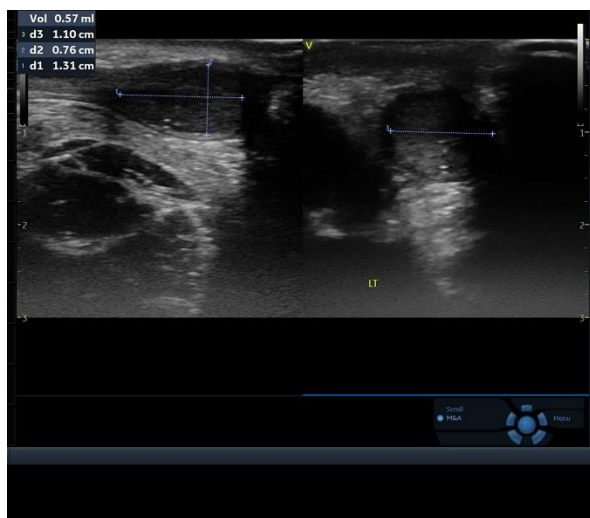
Longitudinal and transverse ultrasound scan of the left testis showing reduced left testicular volume.
